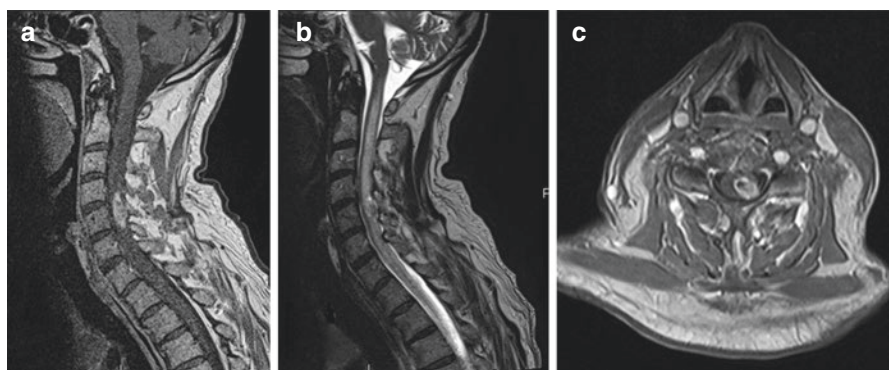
Non-small lung cancer intramedullary metastasis. (a) Preoperative T1-weighted post-contrast sagittal MRI of the cervical spine showing tumor at C4–C5. (b) Sagittal T2-weighted preoperative MRI showing same tumor and adjacent spinal cord edema. (c) Post-contrast, T1-weighted axial MRI showing left-sided intramedullary tumor. (d) Post-contrast, sagittal, T1-weighted MRI showing tumor resection. (Note the fat graft dorsal to the dura to avoid cerebrospinal fluid leak or pseudomeningocele.) (e) T2-weighted postoperative MRI showing tumor resection and fat graft dorsal to the dura. (f) Postoperative, post-contrast T1-weighted MRI showing tumor resection and fat graft
